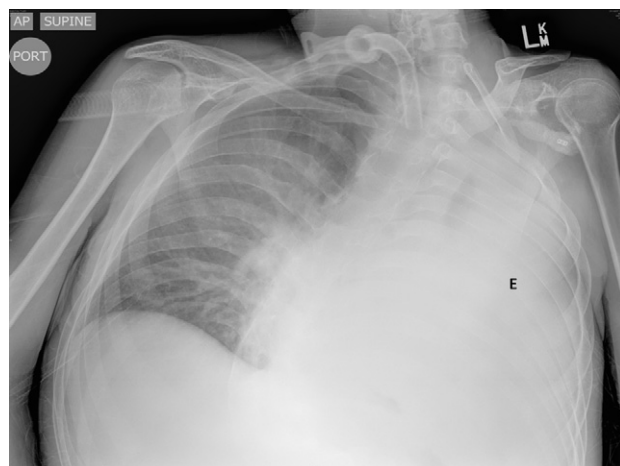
Chest radiograph showing complete opacification of left pleural space. E, Empyema.
